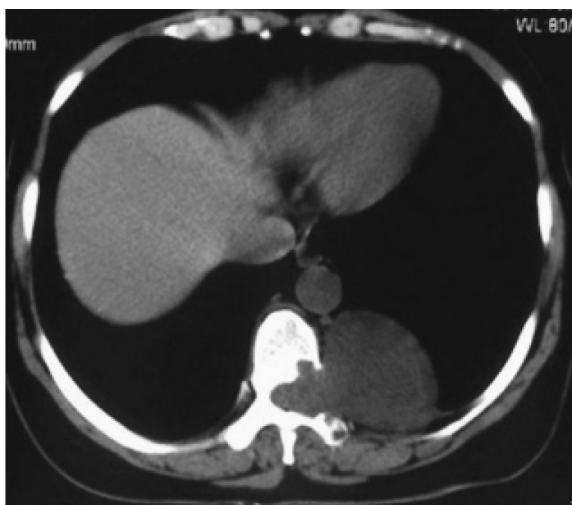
Chest CT scan demonstrates dumbbell tumor at the T9/10th thoracic vertebral level on the left side.
